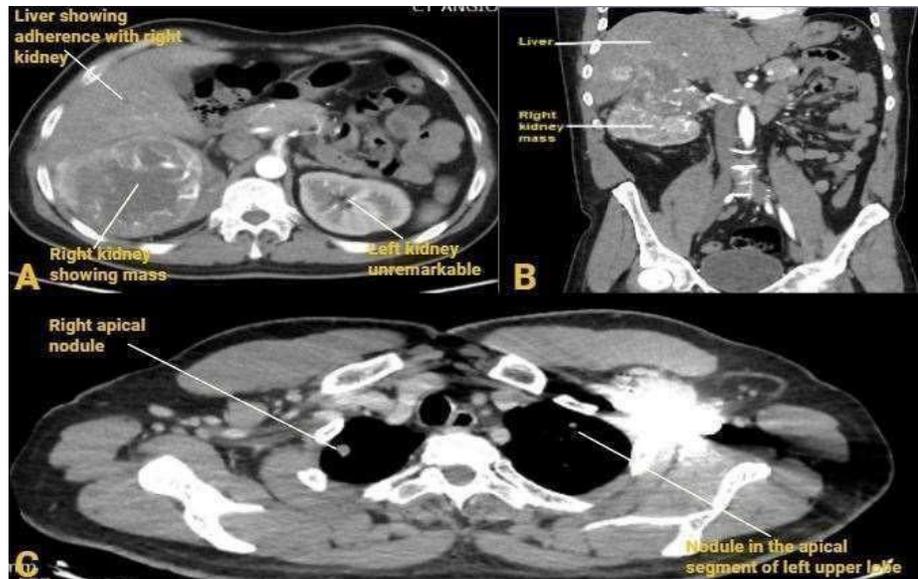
Contrast-Enhanced CT Features of Locally Advanced Renal Cell Carcinoma with Tumor Thrombus and Emerging Pulmonary Metastases
